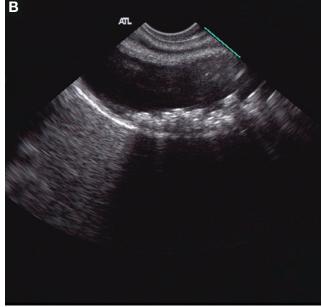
Microlithiasis on Endoscopic Ultrasonography. A, The crystals appear as floating hyperechoic foci that move when abdominal pressure is applied to the right upper quadrant and as layering material representing sludge. B, Note the presence of a shadowing stone with layering sludge.
